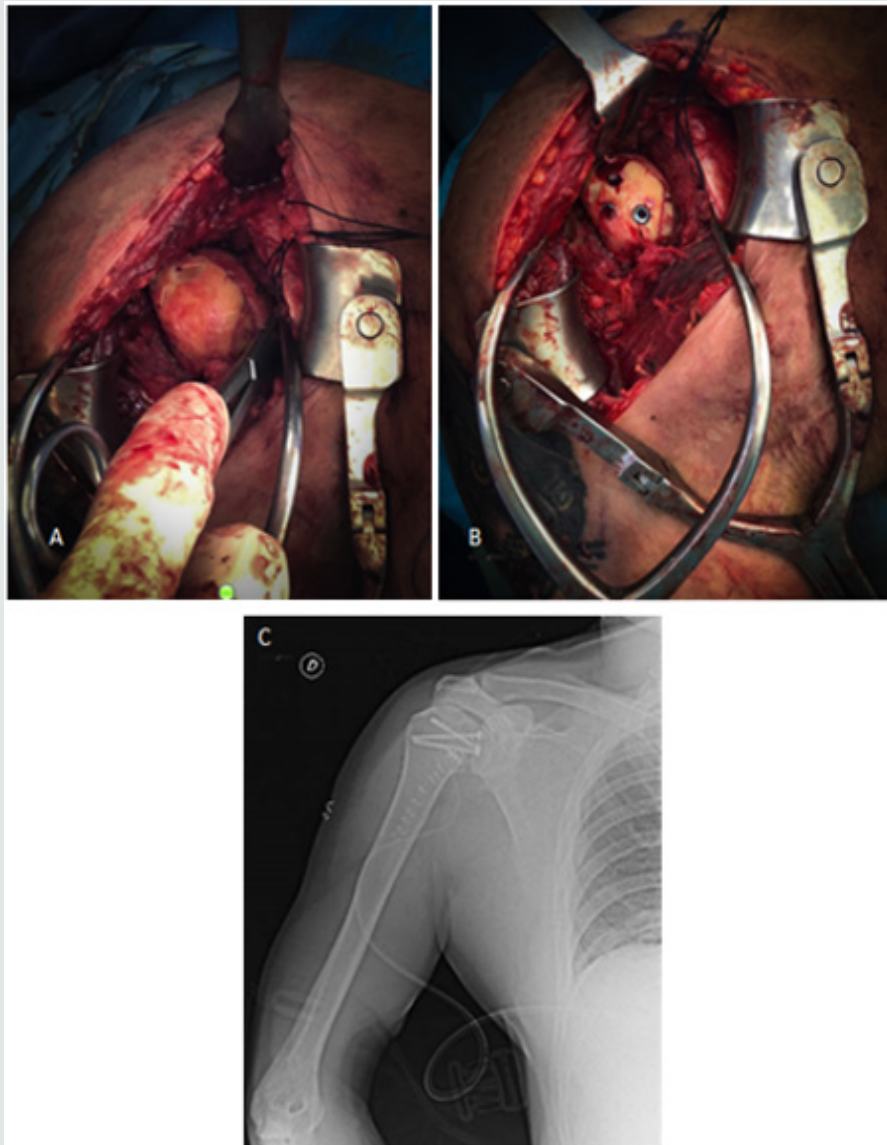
A-C: A and B Intraoperative press-fit of humeral head allograft; C Postoperative X-Ray.
